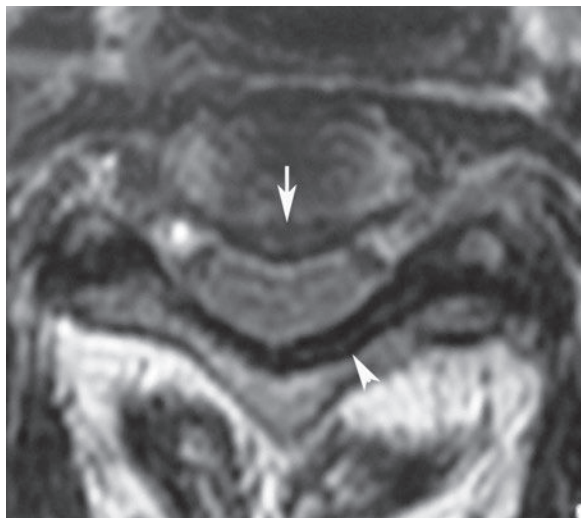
An axial T2-weighted image at the C5-C6 level shows a central disc bulge (*arrow*) with moderate stenosis. The disc bulge and ligamentum flavum hypertrophy (*arrowhead*) act to produce effacement of the ventral and dorsal CSF spaces and deformity of the spinal cord.[†]
